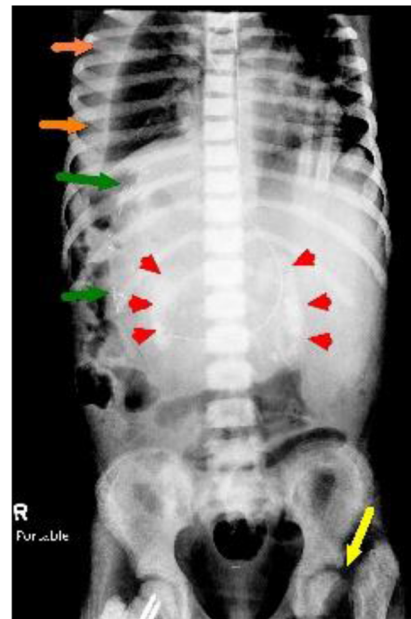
A frontal radiographic image found bilateral cortical nephrocalcinosis (red arrowheads), pathological fracture of the left proximal femur (yellow arrow) and surgical clips related to liver transplantation (green arrows)
